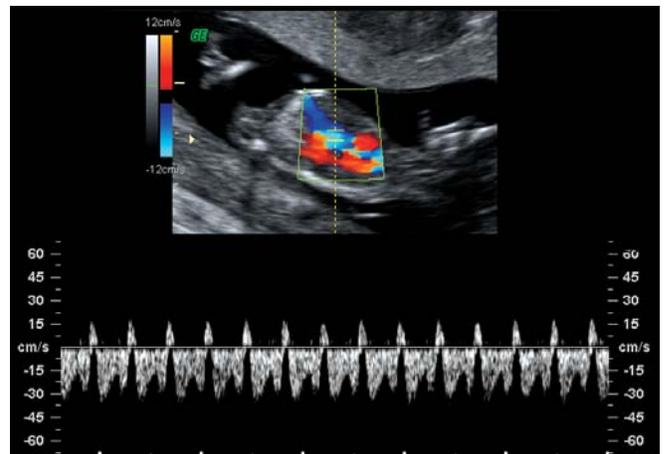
First trim combined NT screening, ductus venosus Doppler: reverse flow during atrial contraction
